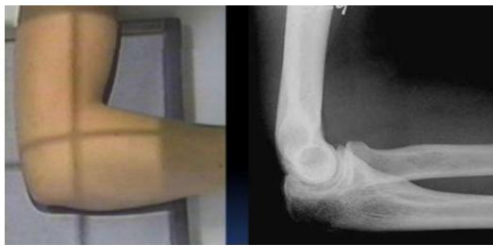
Position and radiographic image of the elbow in lateral projection.
